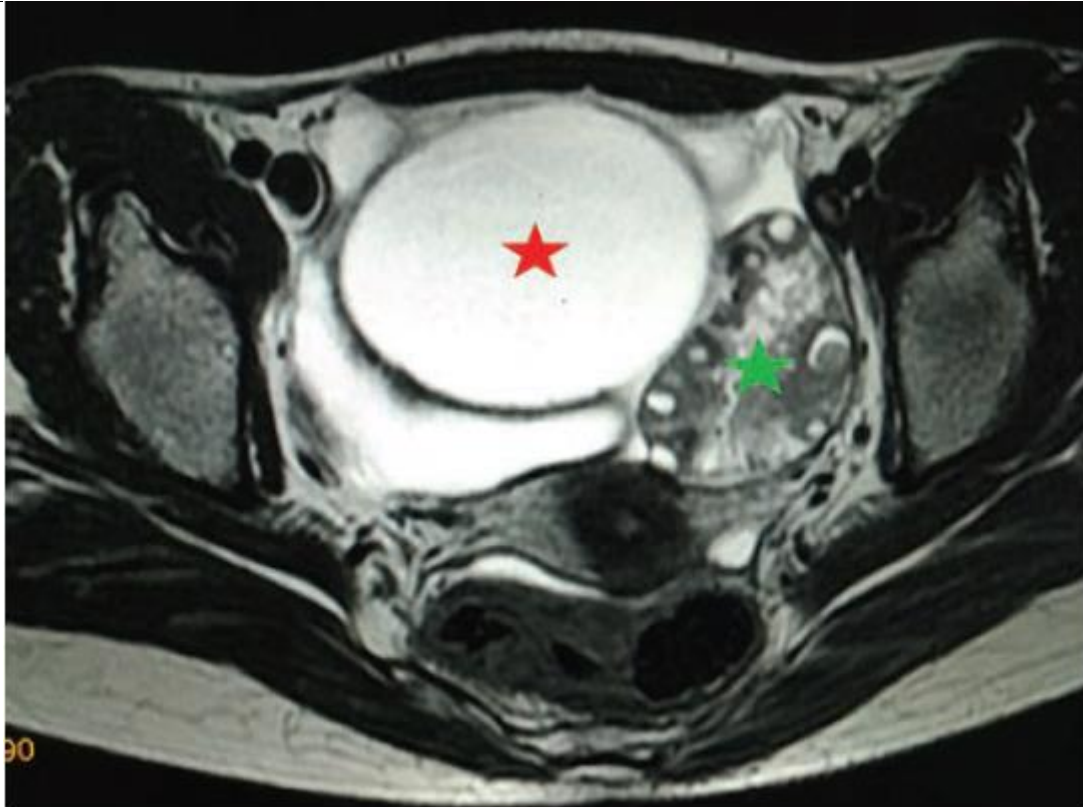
Axial T2-W MRI demonstrating a well-defined hyperintense left paraovarian cystic lesion (red star) with twisted ovarian pedicle and bulky left ovary (green star), possibly torsion of left ovary. MRI, magnetic resonance imaging.
